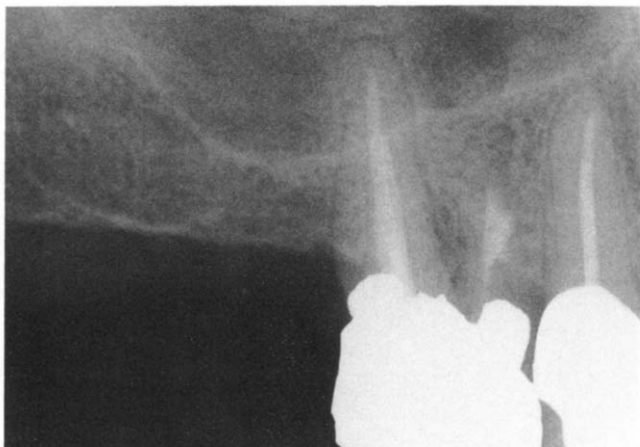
A 15-month recall radiograph shows restitution of normal structures around the mesiobuccal and palatal root apices.
